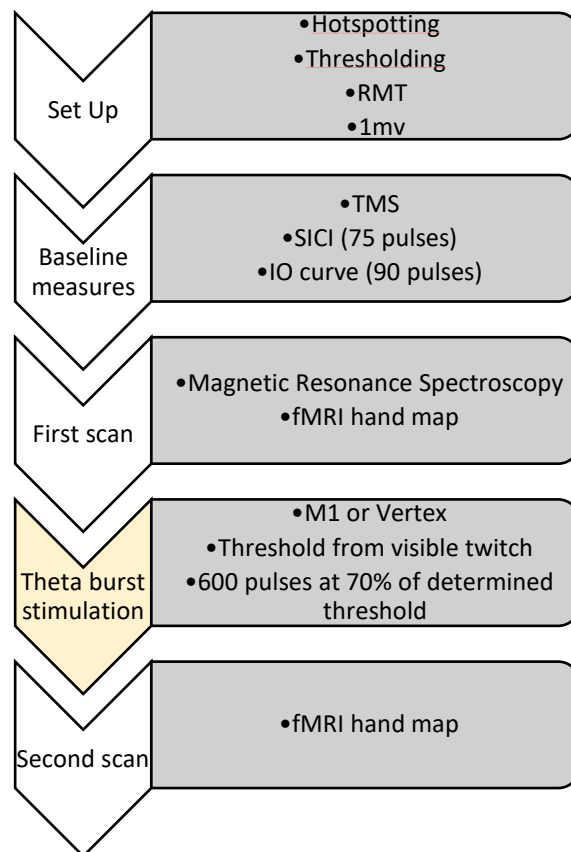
A representation of the experimental procedure undertaken in Session 1, where the application of TBS is combined with MRI scans.
